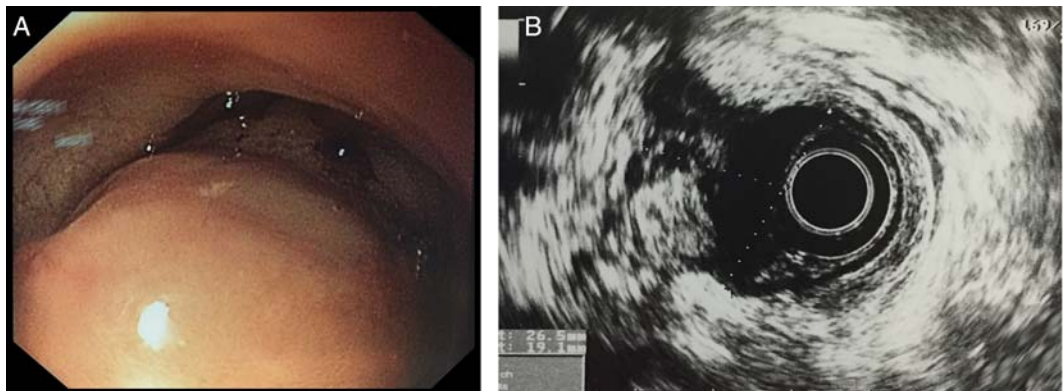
(A) Endoscopic view of a bulging, mostly submucosal lesion about 19 cm from the anal margin. (B) Detail of endoscopic ultrasound showing the same lesion disrupting all layers of the intestinal wall.
